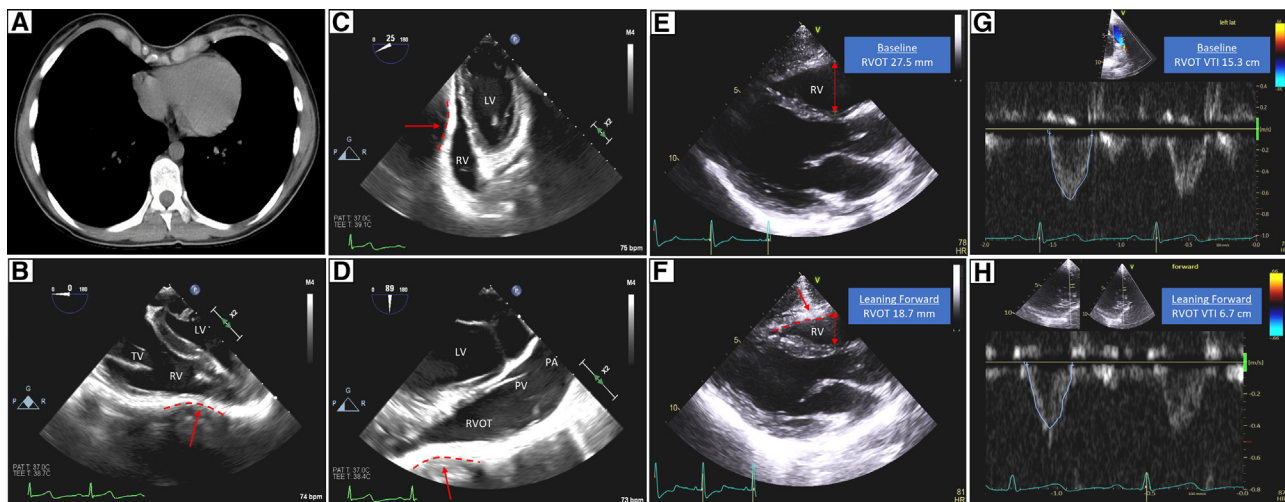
A, Axial computed tomography view showing external right heart compression by the lower costal cartilages. B-D, Intraoperative transesophageal echocardiography demonstrating significant external compression (red arrows and dotted lines) and right ventricle outflow tract (RVOT) diameter reduction. E, Preoperative transthoracic echocardiogram (TTE) image with the patient in the supine position showing minimal right ventricular compression (red double sided arrow). F, Preoperative TTE image with the patient leaning forward showing clear evidence of how the inward displacement of the lower costal cartilages causes an increased right ventricular cardiac compression (red arrow and dotted line) with decrease in the diameter of the RVOT (red double sided arrow). G, RVOT velocity-time integral estimated in the supine position, showing decreased right ventricle stroke volume due to external right heart compression. H, RVOT velocity-time integral estimated with the patients leaning forward revealing a more significant drop.
